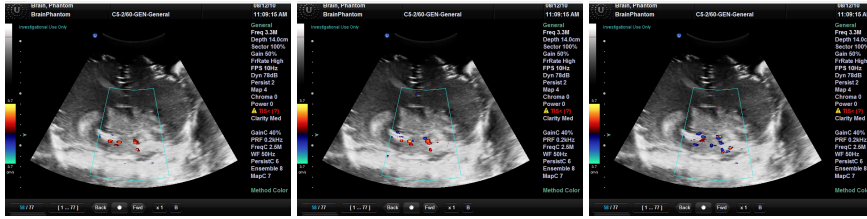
The Doppler Ultrasound shows the flow of water through the tube system, the color indicates the intensity and the direction.
